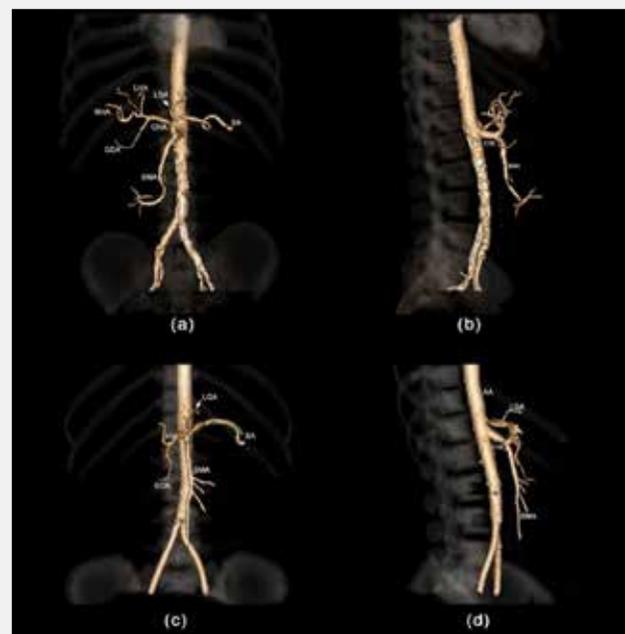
Celiac mesenteric trunk (CMT) types: (a) coronal (b) sagittal 3D reformat computed tomography (CT) images of CMT type 1 (hepato-gastro-spleno-mesenteric trunk); (c) coronal (d) sagittal 3D reformat CT images of CMT type 1 (hepato-spleno-mesenteric trunk with left gastric artery arising from the abdominal aorta)
